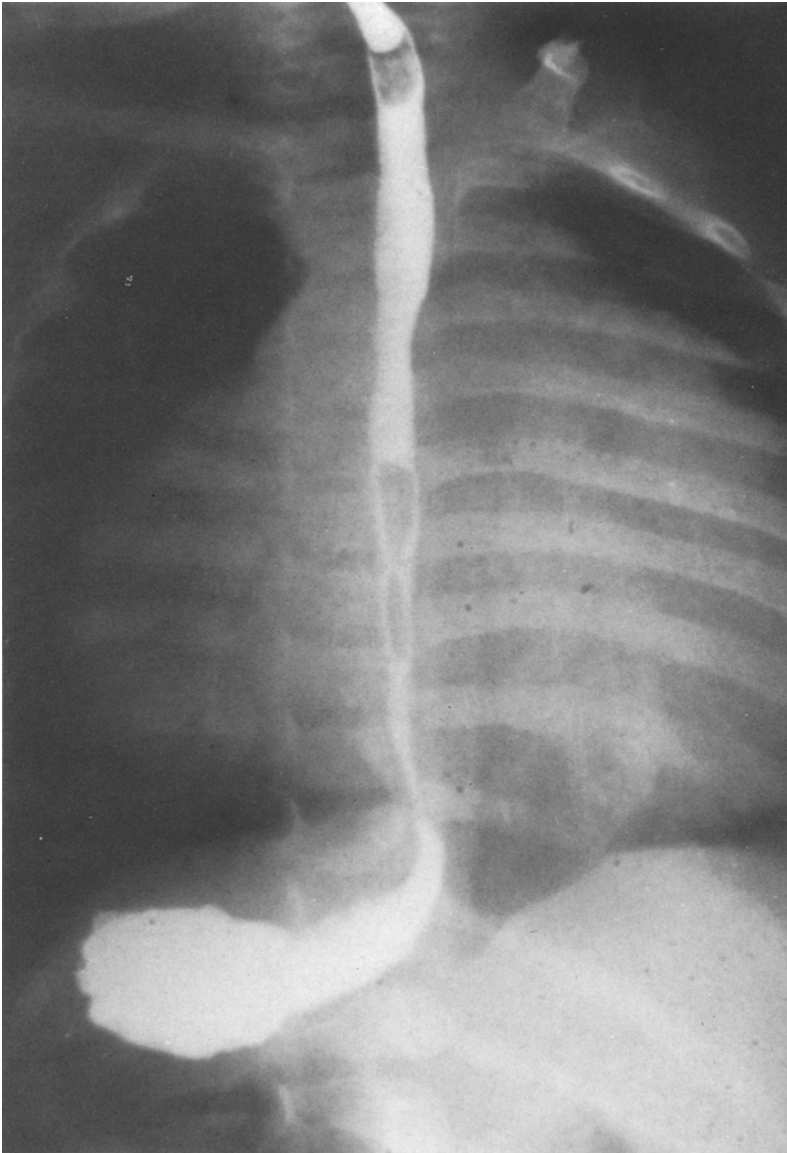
Case 3. Barium swallow X-ray examination shows the right-side stomach
